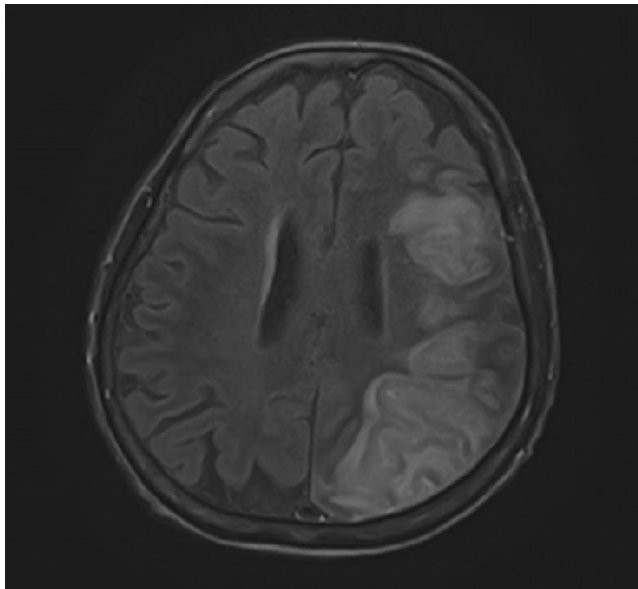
MRI axial FLAIR image
